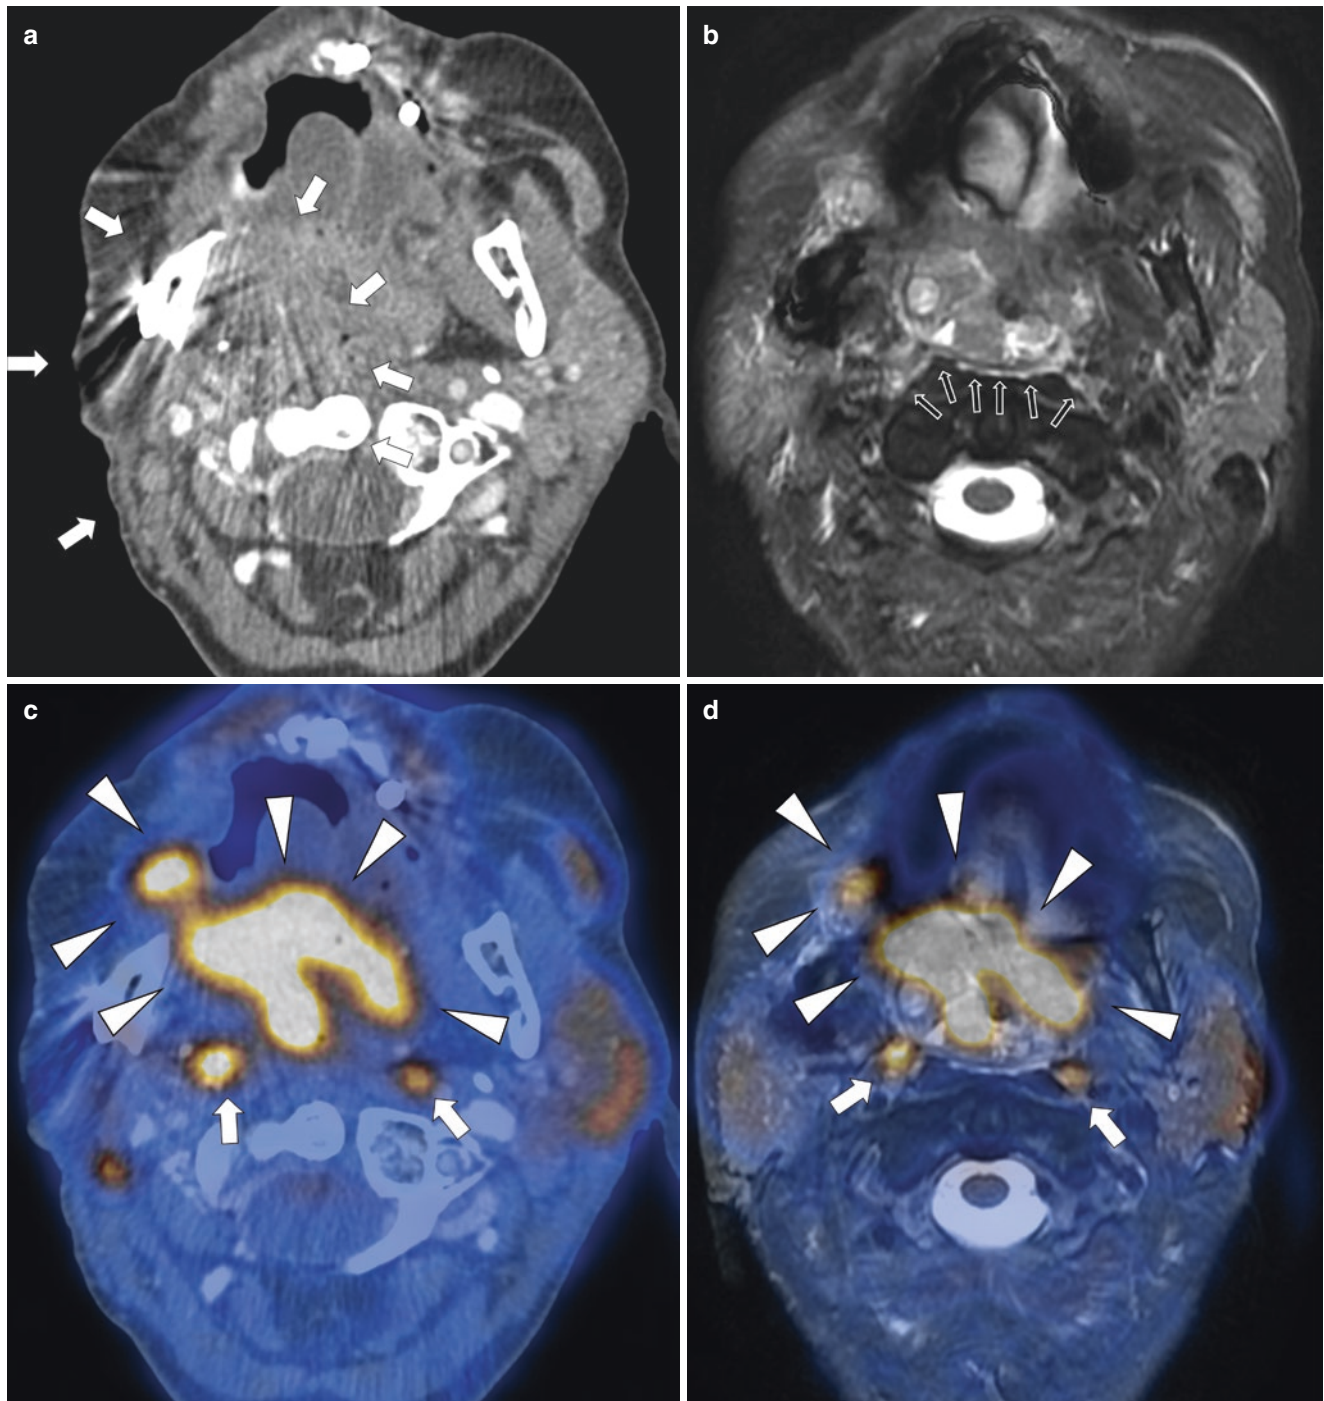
A 59-year-old woman with recurrent squamous cell carcinoma of the floor of the mouth. The severe artifacts from dental implants on CT limited the interpretation of tumor extension (a, *arrows*). PET overlay added information about tumor activity (c, *arrowheads*); however, the anatomical information was still limited on these images. In contrast, on T2WI, an almost continuously defined thin hyperintense line between the tumor and the prevertebral muscles was seen (b, *thin arrows*). With this finding having a high negative predictive value for the absence of prevertebral invasion, the lesion was correctly diagnosed
